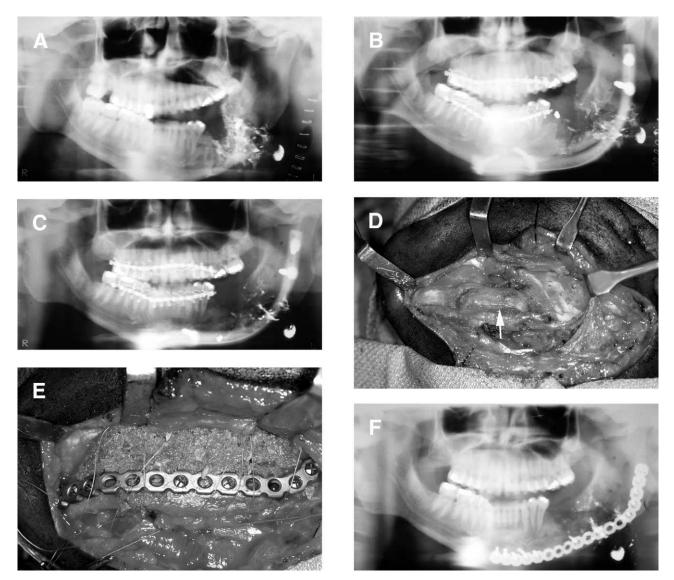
Panoramic radiograph of a patient with a gunshot wound to the left mandibular boyd/ramus, avulsing some of the bone and fragmenting what was left (A). The patient was placed into NMF while external pin fixation was applied. A postoperative radiograph shows the segments have been stabilized and the patient has not been placed into postsurgical NMF (B). Unfortunately but not surprisingly, this patient developed a nonunion. A radiograph taken 6 weeks after surgery shows that bone is present along the inferior border but it is of poor quality (C). Bone graft reconstruction was therefore necessary. The patient was first placed into MMF and an extraoral approach to the mandible was used to expose the fracture site. (D) Consolidation of the basal bone (arrow), which is of a soft, callus-like quality. A reconstruction bone plate was adapted and the occlusion checked before adding bone graft to the defect (E). The patient healed uneventfully after that and a radiograph taken 6 weeks later shows consolidation of the graft (F).
